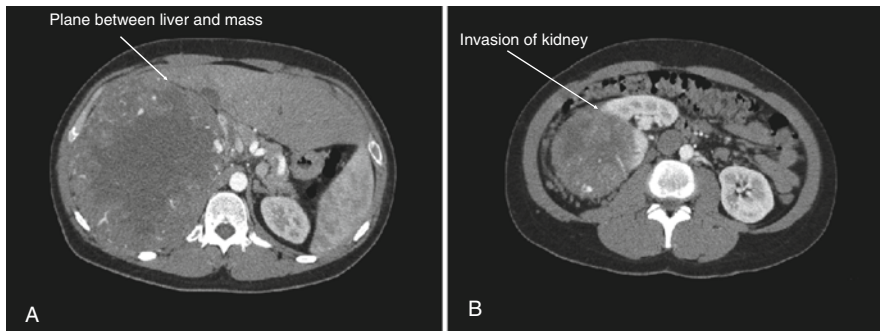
(a) CT showing large right ACC invading the liver and compressing abdominal contents to the left side of the abdomen. (b) Tumor extends inferiorly to invade the right kidney. Patient underwent right adrenalectomy, nephrectomy, and partial hepatectomy
